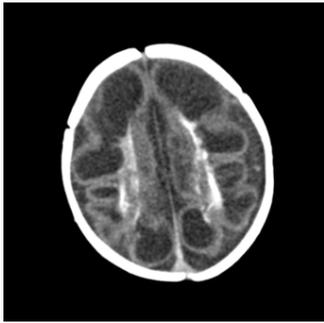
Sagittal section CT brain showing cystic lesion with periventricular hyper densities.
